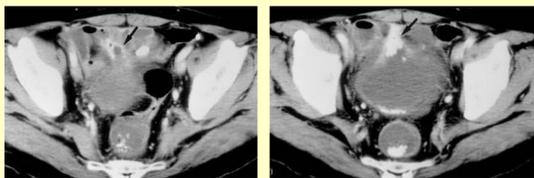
Small bowel CT sections reveal an irregular fistulous tract which causes the leakage and the retention of the contrast medium in the bladder.
